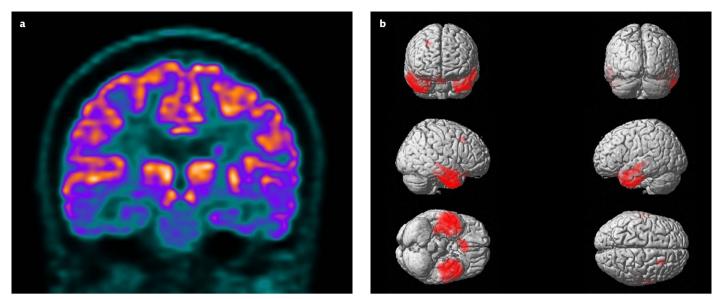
a, b. [18F] fluorodeoxyglucose PET/MR imaging findings in semantic variant frontotemporal dementia. A 58-year-old female patient was seen due to 7 years of progressive tactlessness, lack of empathy, and naming problems for rarely used objects. In the coronal cross-section image of PET, glucose hypometabolism in the temporal cortices (left>right) and frontal cortex of the patient is evident, patient's brain MRI showed frontotemporal (especially in the left anterior temporal cortex) cortical atrophy, (a) these findings are also evident in the quantitative analysis performed by SPM method (b).
